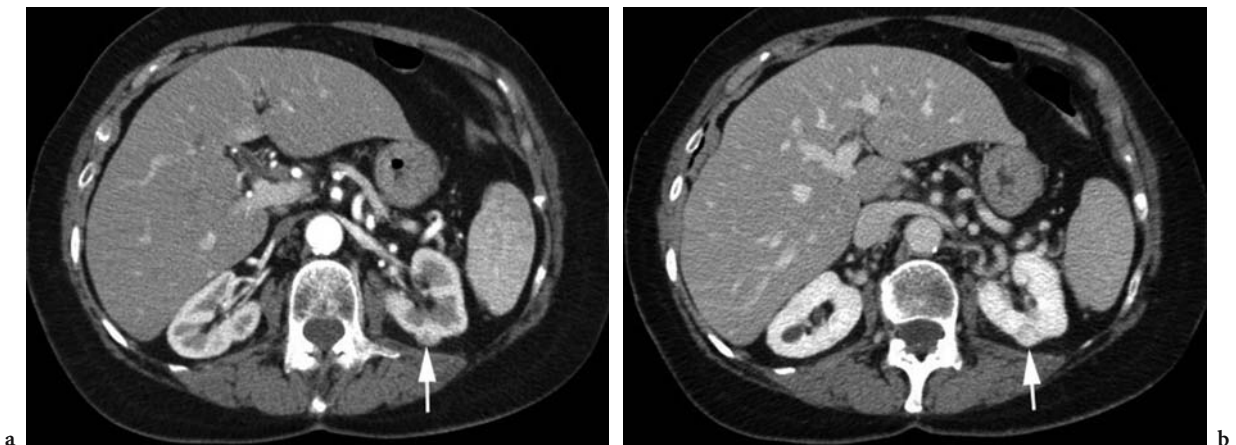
Oncocytoma in a 75-year-old woman with history of breast carcinoma. a Axial contrast-enhanced CT scan at corticomedullary differentiation phase incidentally detects a 1.5 cm left renal mass (*arrow*). b This mass is better seen at nephrogram phase (*arrow*). Core biopsy pathology prior to radiofrequency ablation was consistent with oncocytoma rather than granular cell or chromophobe carcinoma.
